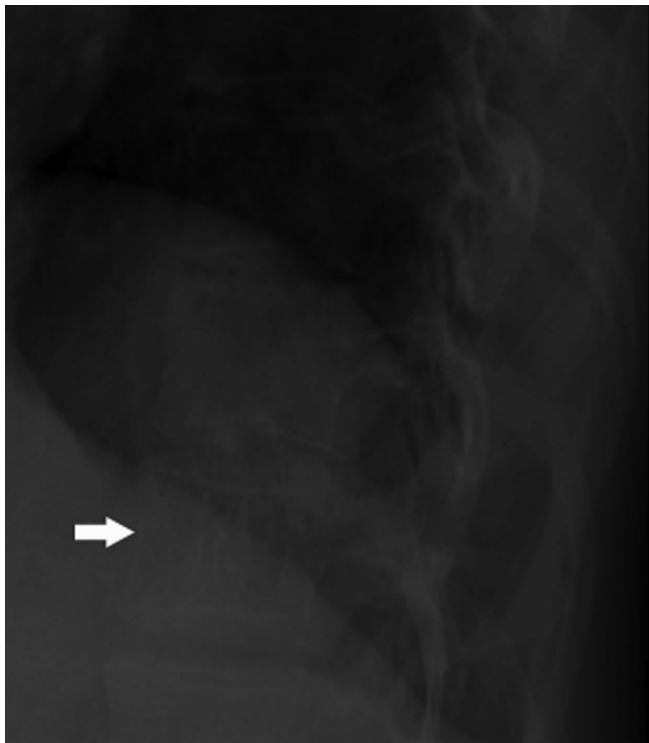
A 75-year-old man presented with lower back pain after a mechanical fall. Thoracic spine radiographs in the lateral projection, showing a typical hemangioma (arrow) at the T12 vertebral body with classic corduroy appearances.
